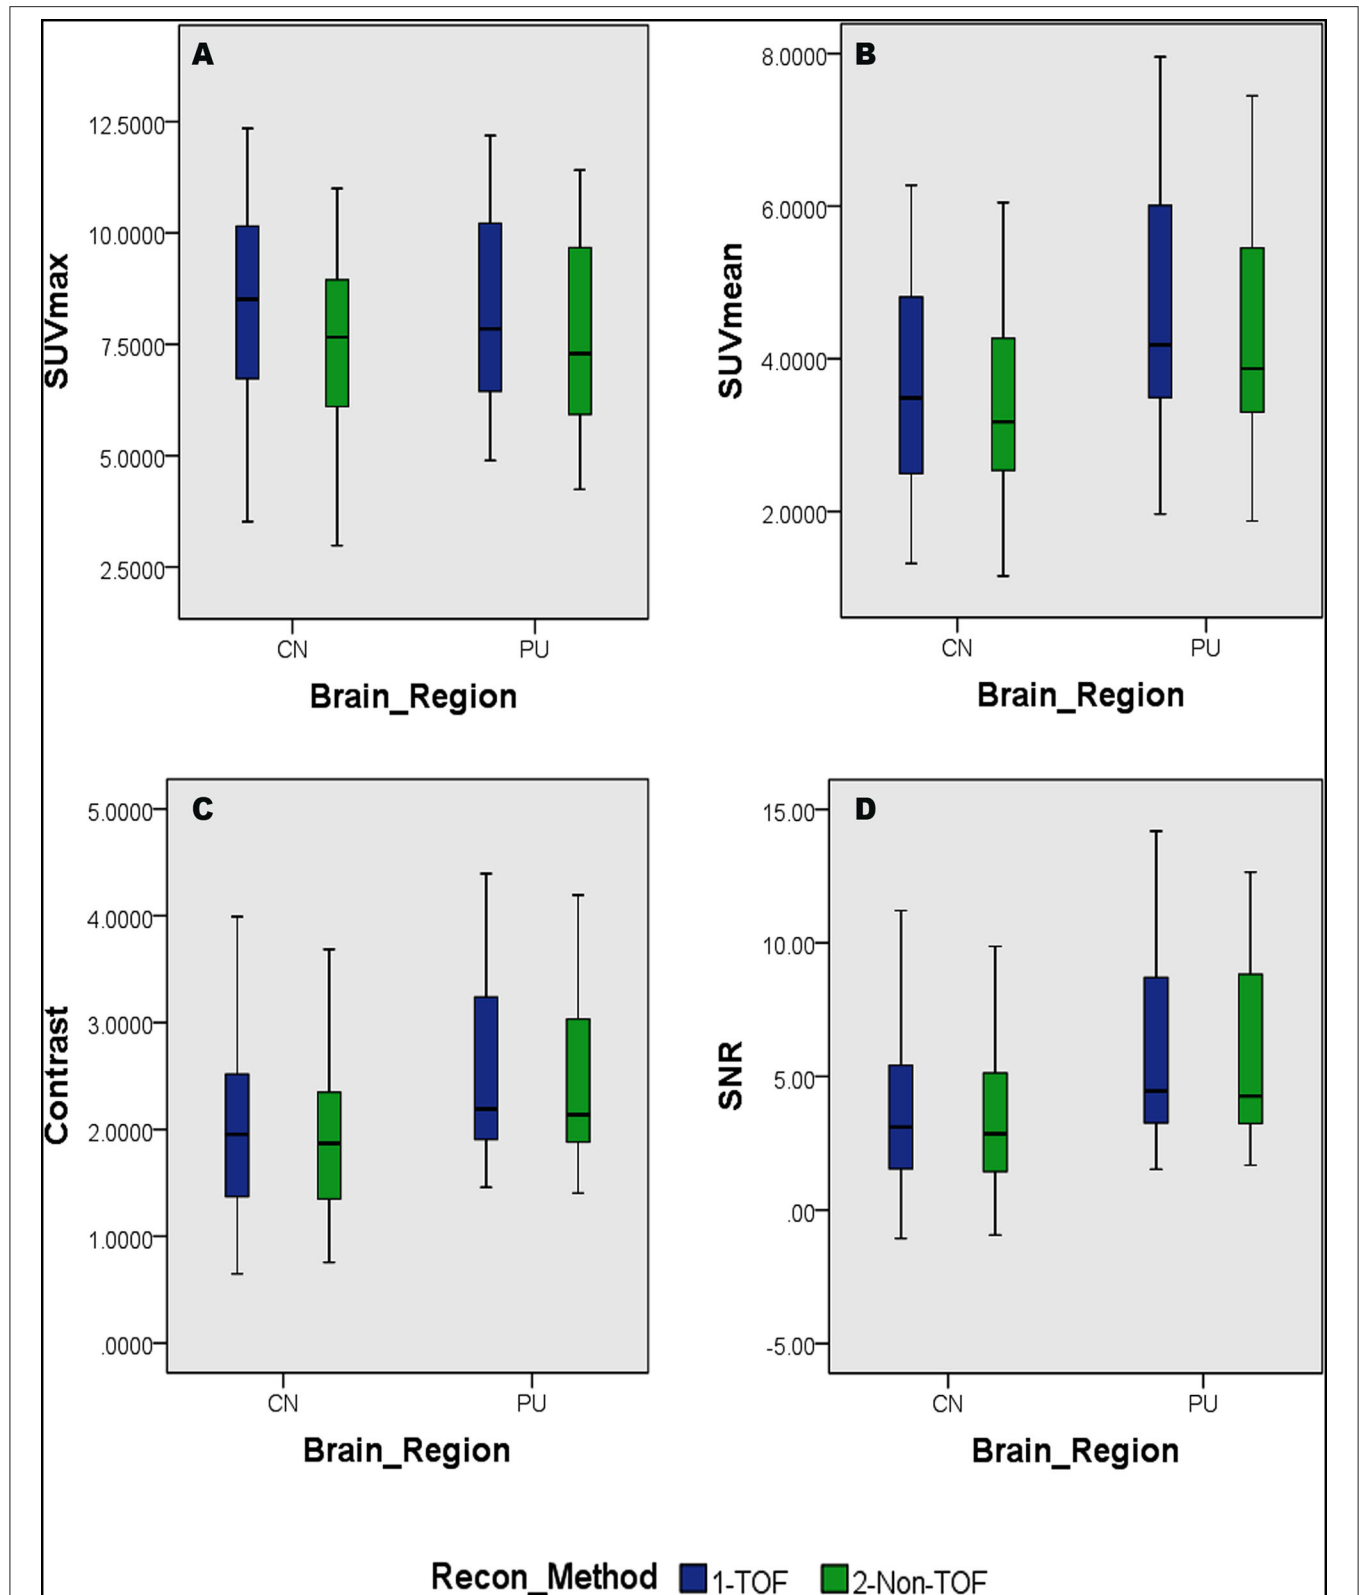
Distribution of the SUVs and quantitative parameters with reconstruction methods per each brain regions of ^{11}C -PFT brain PET; (A) shows the distribution of individual subject's SUVmax values per segmented brain volume of interests (VOIs); (B) shows the distribution of individual subject's SUVmean values per segmented brain VOIs; (C) shows the distribution of individual subject's signal-to-noise ratio (SNR) values per segmented brain VOIs; (D) shows the distribution of individual subject's contrast values per segmented brain VOIs; WB, whole brain; CN, caudate Nuclei; PU, putamen.
